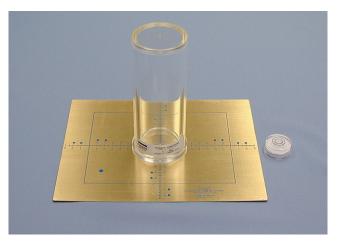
A test tool for monitoring the coincidence of the x-ray beam and light field. (Courtesy Cardinal Health.)
